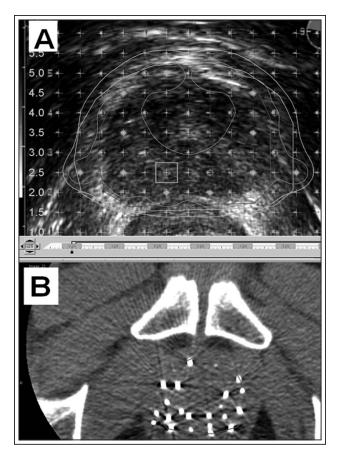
A) Planning ultrasound showing treatment volumes. Contours: orange = 216 Gy, blue = 144 Gy. B) Post-implant CT scan showing LDR iodine-125 transperineal brachytherapy implant of 140 x 0.334 mCu seeds, planned to deliver a modified peripheral dose (MPD) of 144 Gy, maintaining the periurethral dose to < 150% of the MPD.
